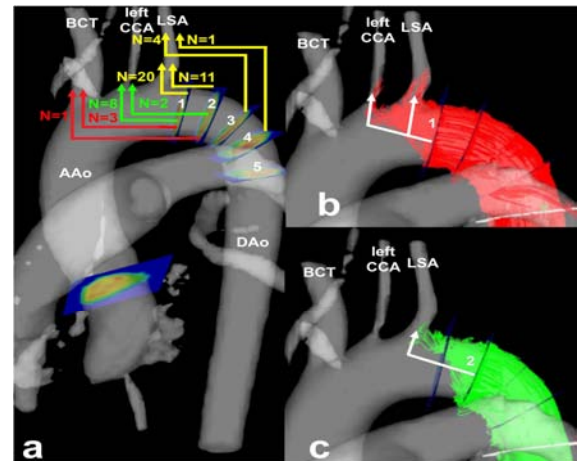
Using 4D flow MRI for visualization of retrograde flow from the descending thoracic aorta into the aortic arch. A- Summary of maximal retrograde diastolic flow distance from each of the five planes positioned in the Aortic Arch and Descending Aorta from the origin of the Left Subclavian Artery. Each plane is separated by 10mm. red=InA, green=LCCA, yellow=LSA. B- 3D streamlines visualization of a 53 year old stroke patient throughout the cardiac cycle emitting from the first plane with regurgitant flow into the LCCA and LSA. C- Same patient as above but with the regurgitant flow emitted from the second plane. (InA = innominate artery; LCCA= left common carotid artery; LSA = Left subclavian artery).
